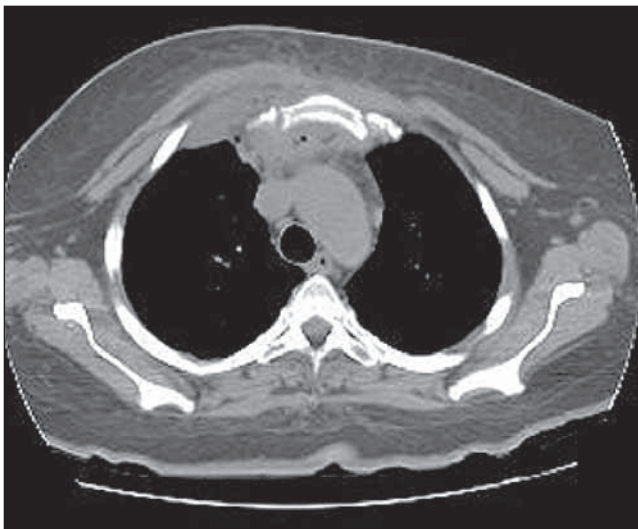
A computed tomographic (CT) scan shows the typical appearance of sternoclavicular joint infection, including fluid collection around the joint and tissue stranding.
